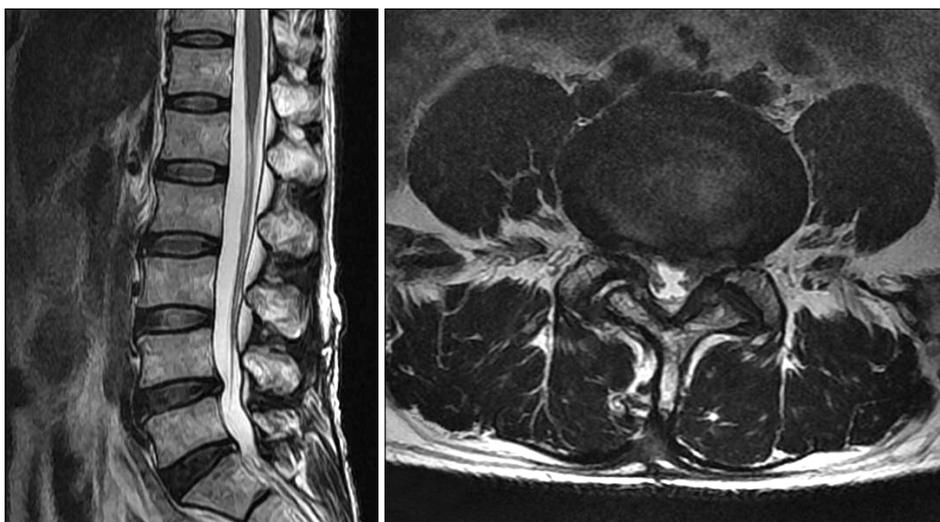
Postoperative images of the lumbar spine. Eight months later, the previously noted lesion is not seen on the postoperative follow-up magnetic resonance image.
